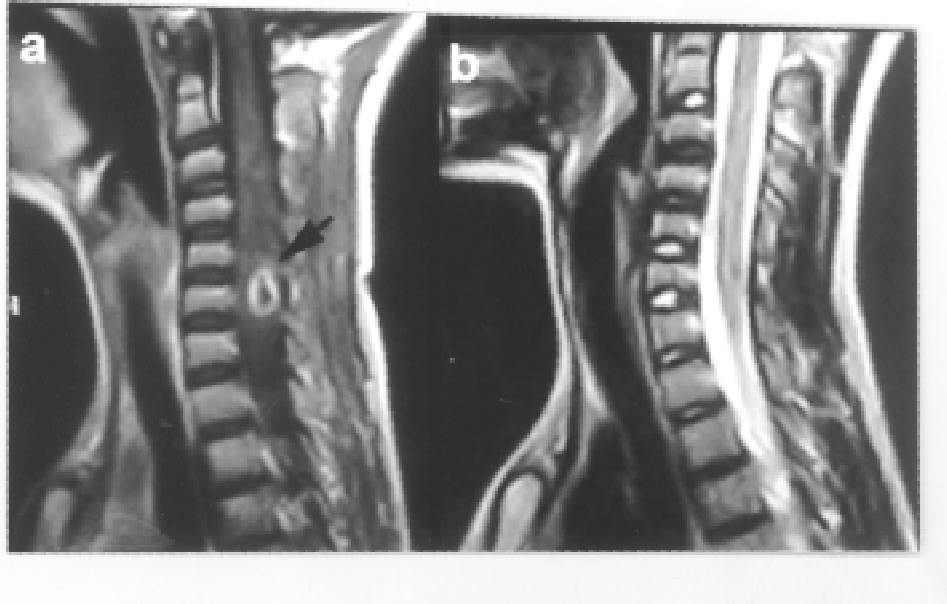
Contrast enhanced MRI of the brain (sagittal view, T1 weighted image) showing intramedullary enhancing ring lesion (arrow) opposite C6 vertebral body (a) before treatment. The lesion resolved completely following nine months of antituberculosis treatment (b).
